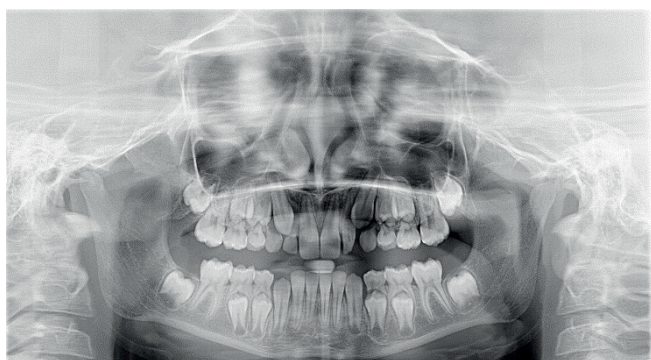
Panoramic radiograph provided by the patient's parents. The patient is 8-years-old
